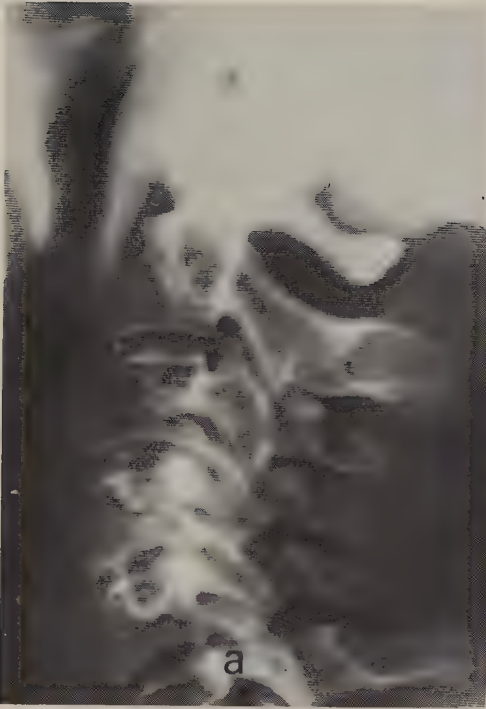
Case 2. a/Lateral radiograph of the cervical spine from 1964, 2 years before appearance of RA. b/Lateral cervical radiograph from 1974 with an anterior atlanto-axial and a vertical dislocation. c/Radiograph from 1979 with a diminished distance from the hard palate to the anterior arch of the atlas (compared with earlier radiographs as measured after correction for magnification). The posterior arch is at the level of foramen magnum. The vertical dislocation has preceded. d/Computed tomography of the foramen magnum level from 1983. Arrows marks the medulla oblongata interposed between the dens and the posterior arch of the atlas, situated in front of the posterior border of the foramen magnum.
